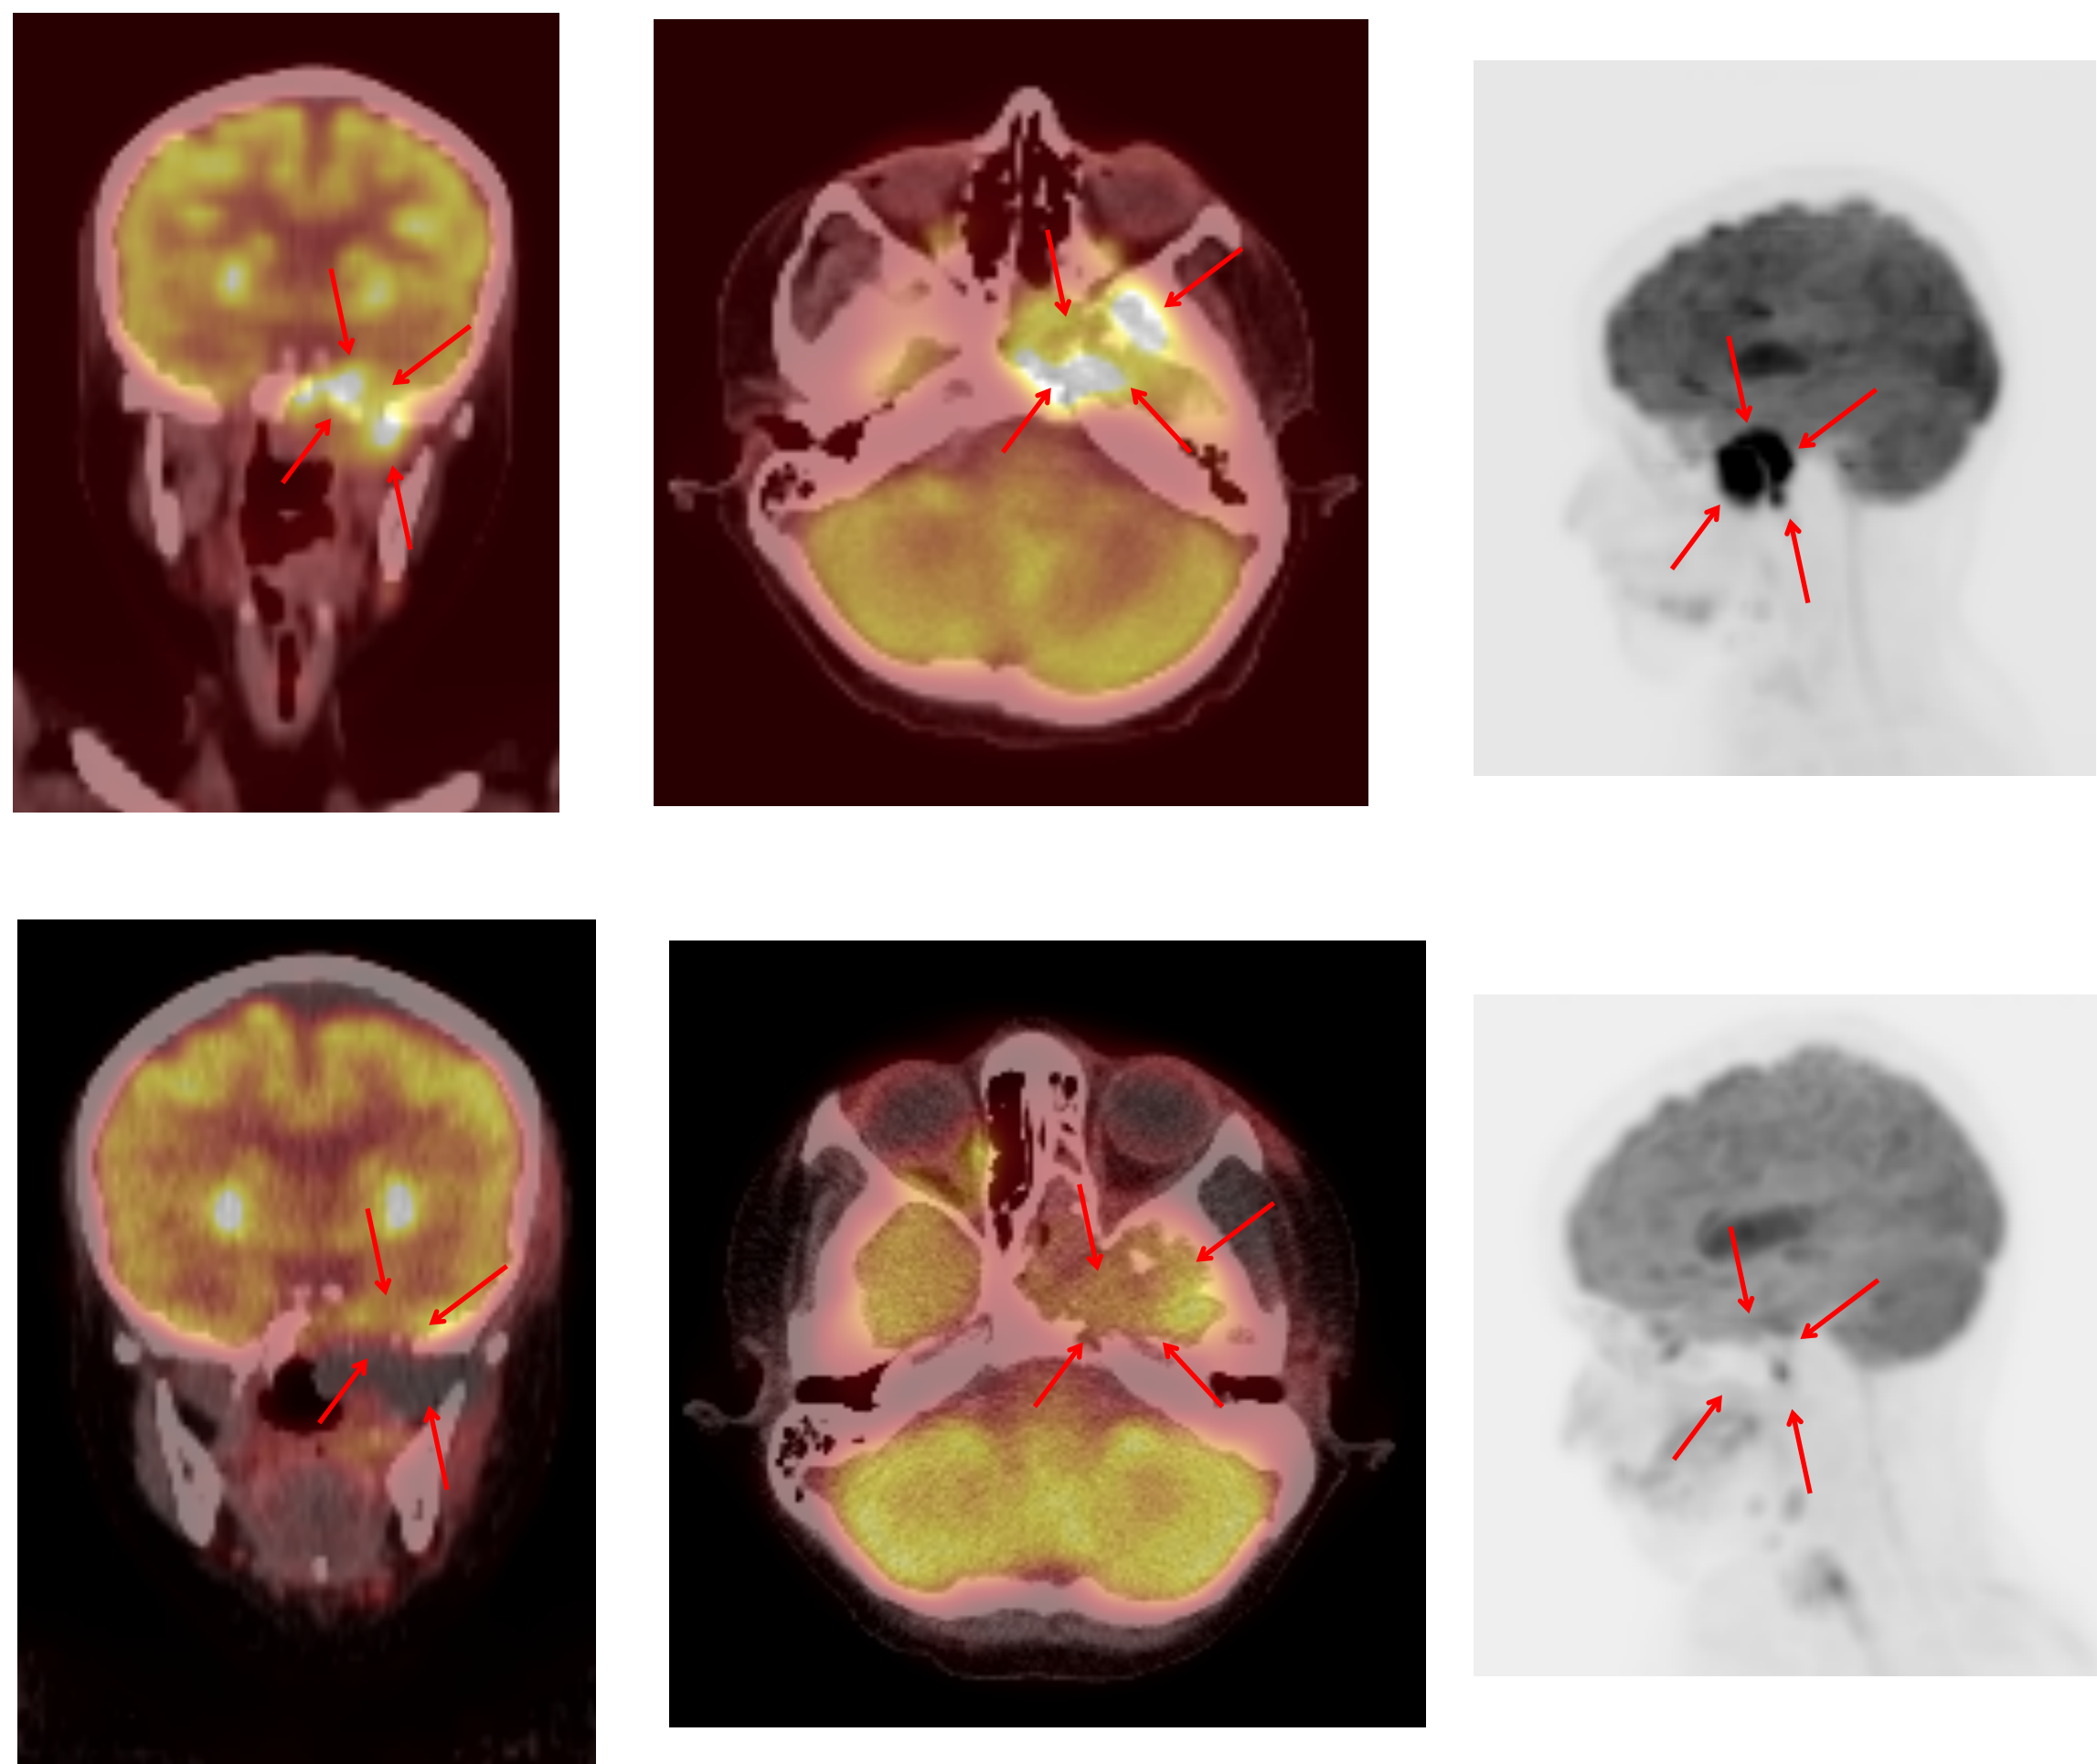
(a) PET-CT of tumor prior to IA chemo; (b) Tumor post 2 rounds IA chemo (cisplatin/doxorubicin)
